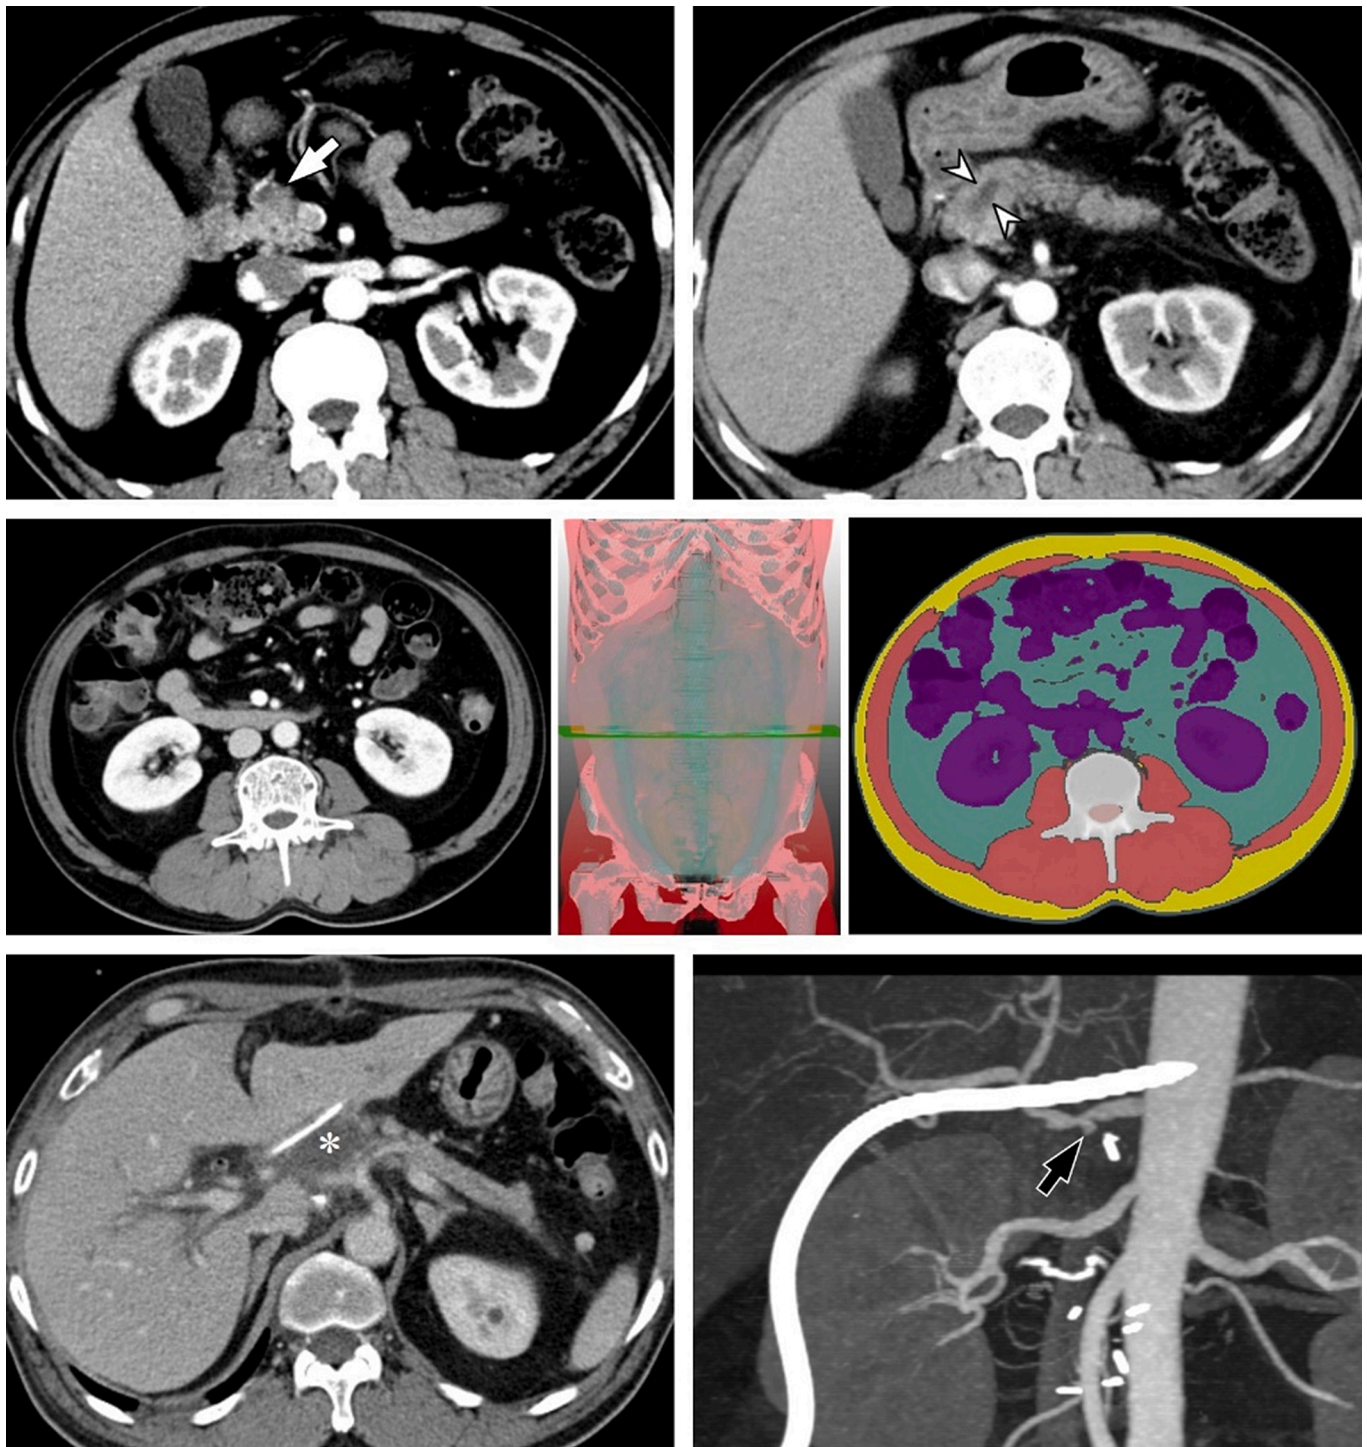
A 57-year-old man who underwent pancreaticoduodenectomy for pancreatic ductal adenocarcinoma. (A and B) Axial late arterial phase images of preoperative CT scan show a 1.8 cm low-attenuated, ill-defined mass in the pancreas head (white arrow) with upstream main pancreatic duct dilatation measuring 6 mm (arrowheads). (C) A portal venous phase image of preoperative CT scan shows an axial image at the L3 vertebral level. (D) 3D translucent image shows a volumetric segmentation of portal venous phase images of preoperative CT. A green horizontal plane indicates the L3 vertebral level. (E) An axial image shows the results of segmentation, which are overlaid on orthogonal cross-sectional images. Red, yellow, green, and purple colors indicate skeletal muscle, subcutaneous adipose tissue (SAT), visceral adipose tissue (VAT), and internal organs, respectively. VAT, SAT, and skeletal muscle indexes of the patient are 66.6 cm²/m², 29.0 cm²/m², 46.6 cm²/m², respectively. (F) Axial CT scan taken on postoperative day 7 shows a small amount of fluid collection (asterisk) around the pancreaticojejunostomy. A surgical drain was repositioned through percutaneous procedures, which indicates postoperative pancreatic fistula grade B. (G) CT angiography taken one month after the surgery shows a 3 mm pseudoaneurysm (black arrow) at the stump of gastroduodenal artery and a stent graft was placed in the hepatic artery.
